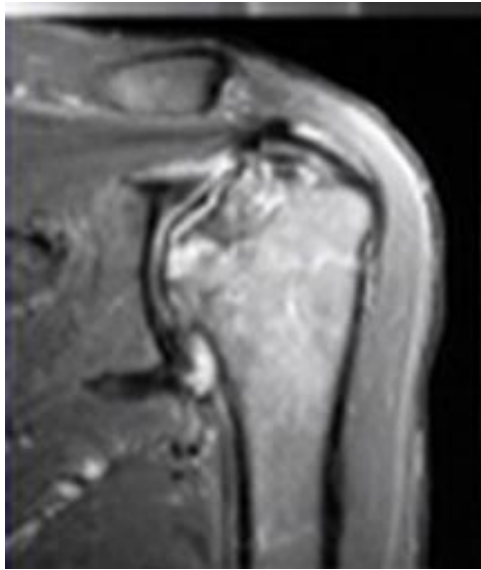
Magnetic resonance (MRI) scan [2]
